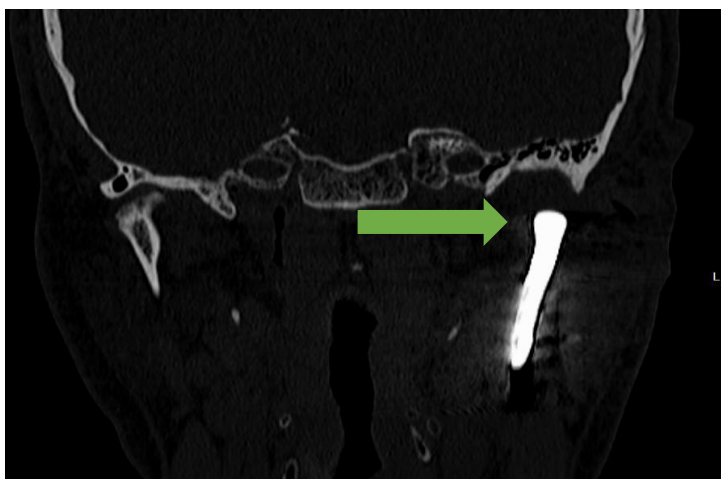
Computed tomography scan, frontal view. Displacement of the implant (green arrow). Radiological examination was performed 2 months after the surgery (RadiAnt DICOM Viewer 2025.2).
